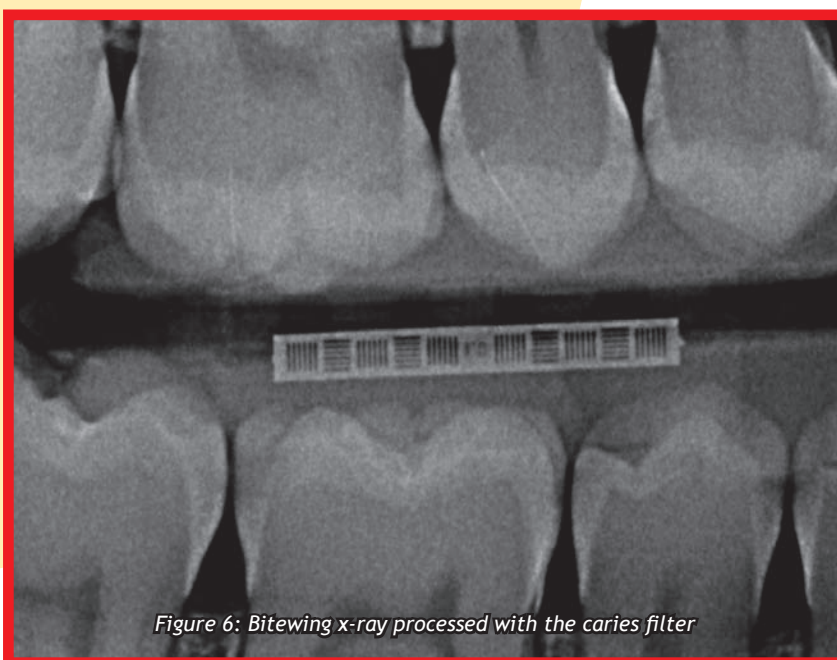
Bitewing x-ray processed with the caries filter
